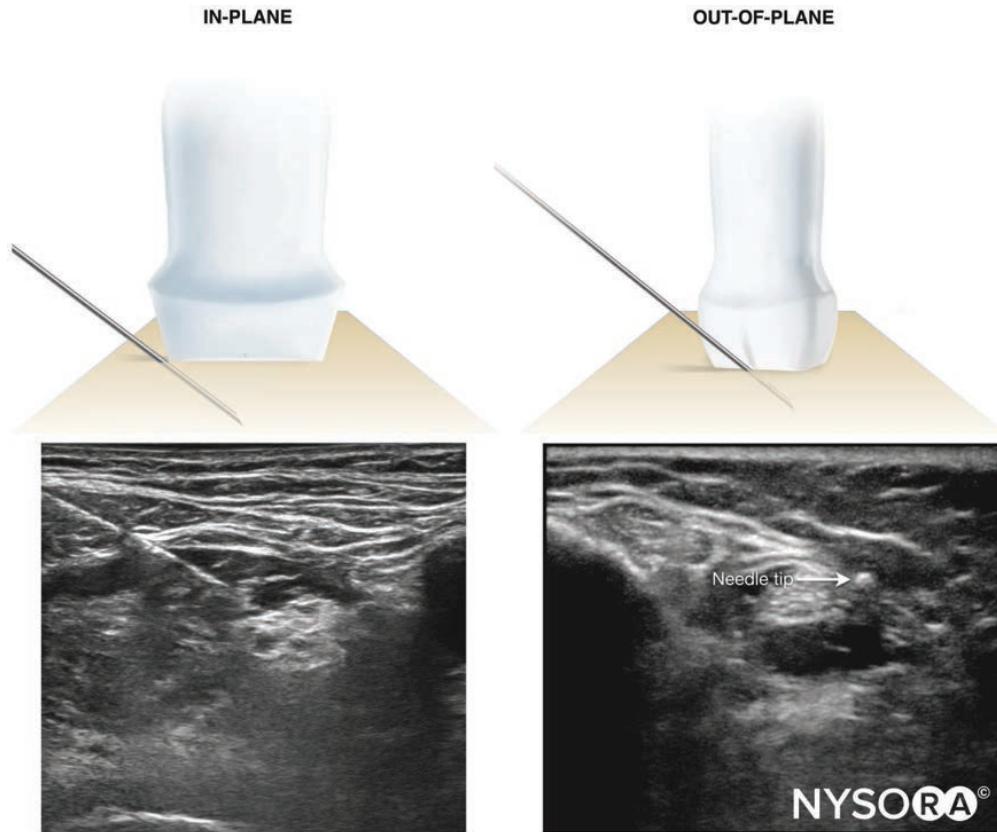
In-plane and out-of-plane needle insertion techniques and their corresponding appearance in an ultrasound image.
